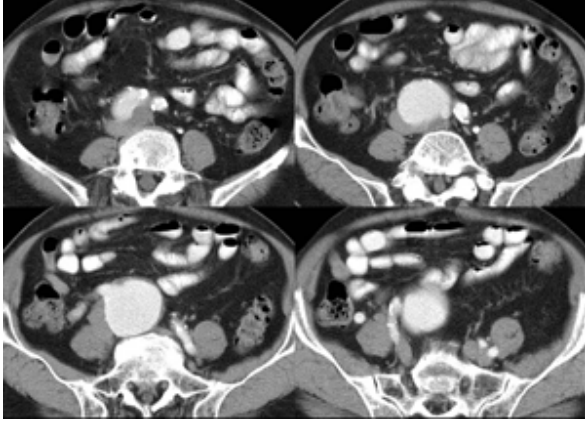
Pelvic CT scan demonstrates a saccular aneurysm originated from right common iliac artery.
